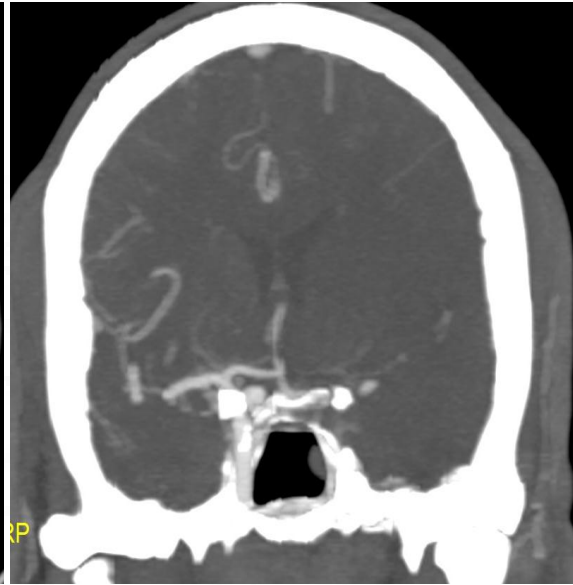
Coronal CT MIP Art. del. phase showing poor col. score (mASITN/SIR grade 1)
